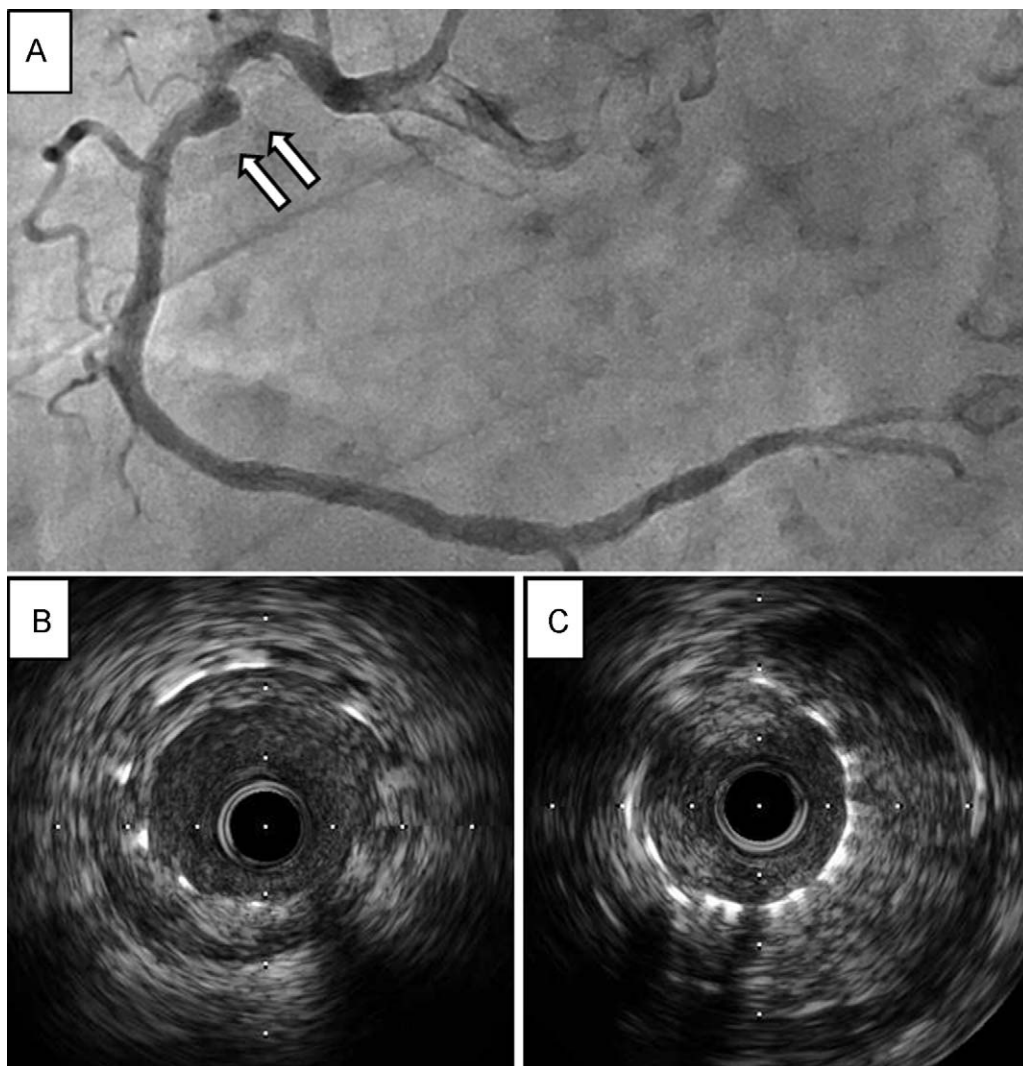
(A) Seven-month follow-up coronary angiography showing coronary artery aneurysm formation at previously stented site (arrows). (B) Intravascular ultrasound appearance of complete strut apposition and neointimal coverage at the distal part of the stent. (C) Intravascular ultrasound imaging of coronary artery aneurysm formation.
